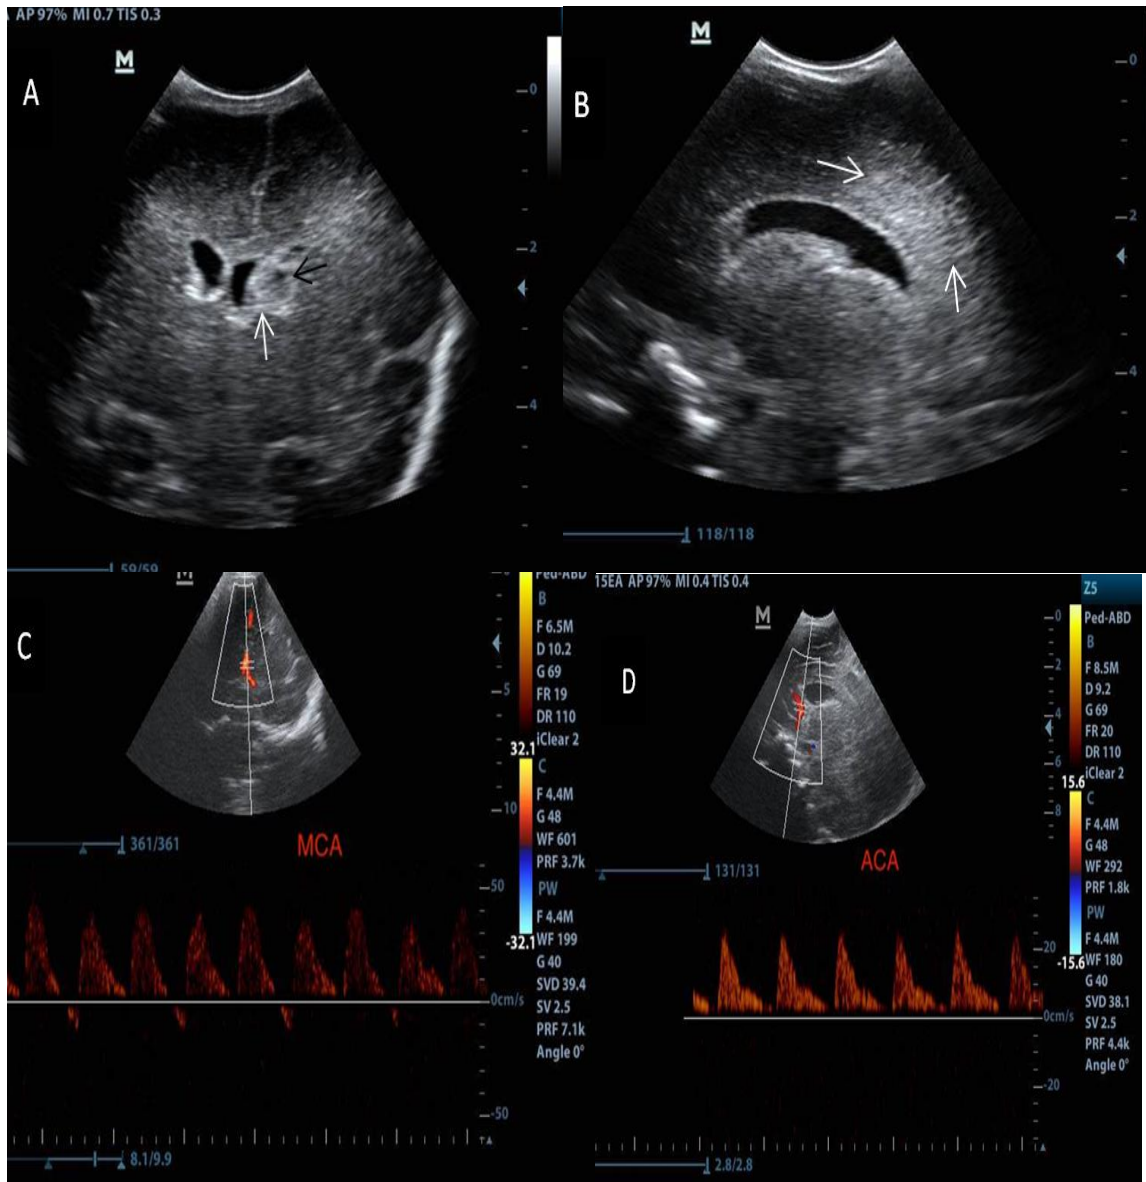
10 days age (on the day scanning) , with mild degree of clinical severity ‘ Sarnat Staging ‘ (stage 1), and 6 (moderately abnormal) Apgar score (Recorded at 5 min). (A) Trans-cranial ultrasound (coronal view) through the anterior fontanelle showing increase periventricular echodensities (arrows) at 10th day denoting PVL grade I. (B) Trans-cranial Doppler ultrasound (TCD) showing pulsed Doppler of the middle cerebral artery (ACA) with RI 0.74. (C) Trans-cranial Doppler ultrasound (TCD) showing pulsed Doppler of the middle cerebral artery (MCA) with RI 0.69.
